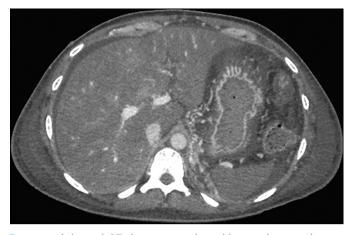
Abdominal CT showing an enlarged liver with patent hepatic and portal veins.
